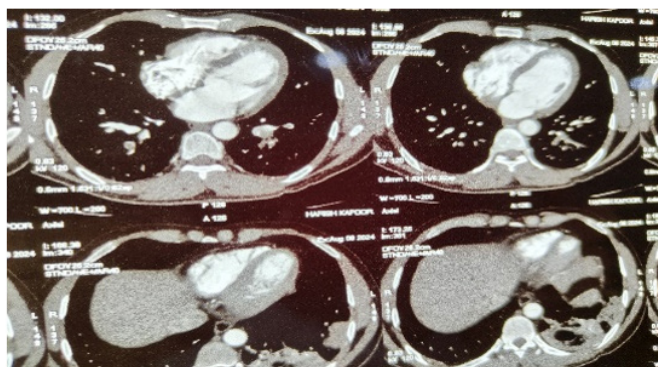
CT thoax: LLL consolidation.
